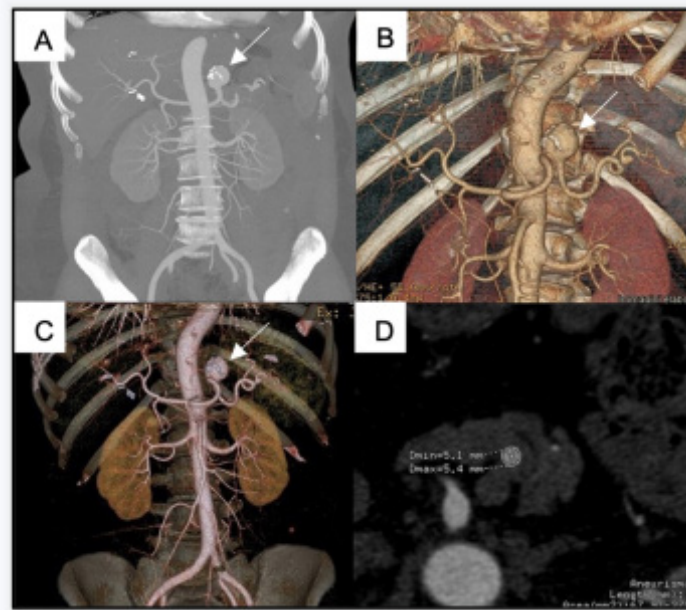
Preoperative CT angiography. MIP (A) and 3D reconstructions (B and C) show a 5 cm splenic artery aneurysm (arrows). The diameter of the splenic artery is 5 mm (D).
